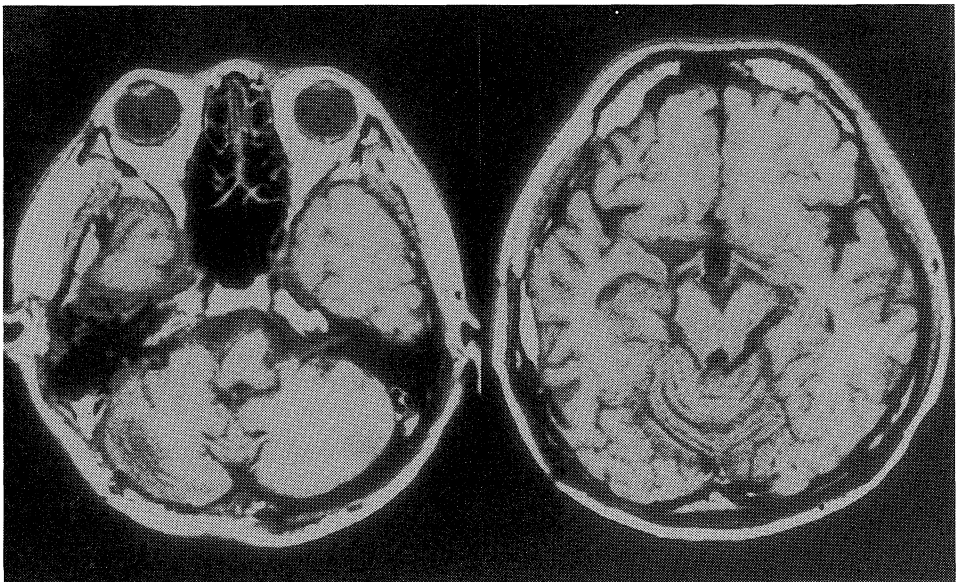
Postoperative MRI demonstrating total removal and improvement of midline shift.
